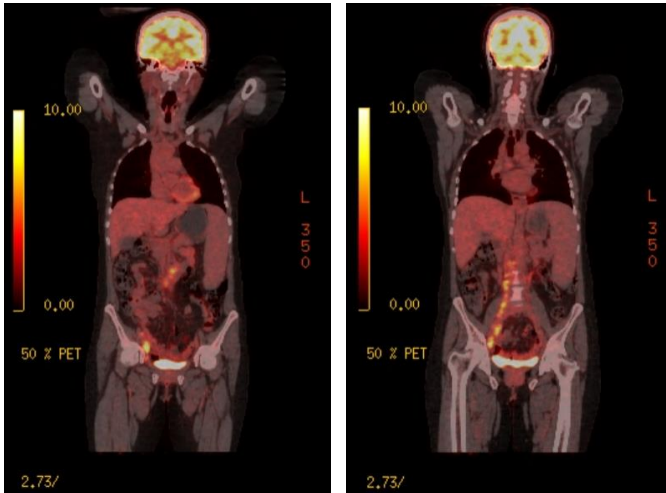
PET/CT images of the patient before the 4th line treatment (recurrence) (New lesions in the abdominopelvic and mediastinal area)
